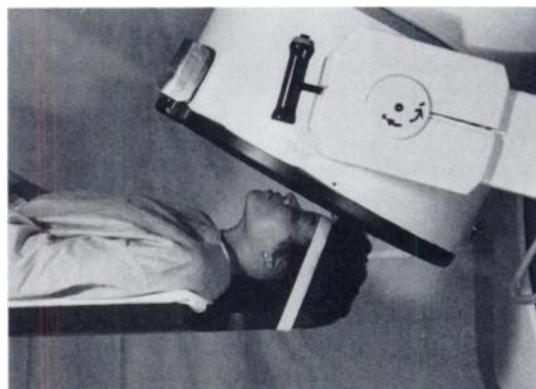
Patient position for A-SPECT head tomogram. Gantry is shown at 0° . Camera head is tilted 30° and remains fixed at this angle while gantry revolves between 0 and 360° . Note close apposition of collimator to patient's head.
